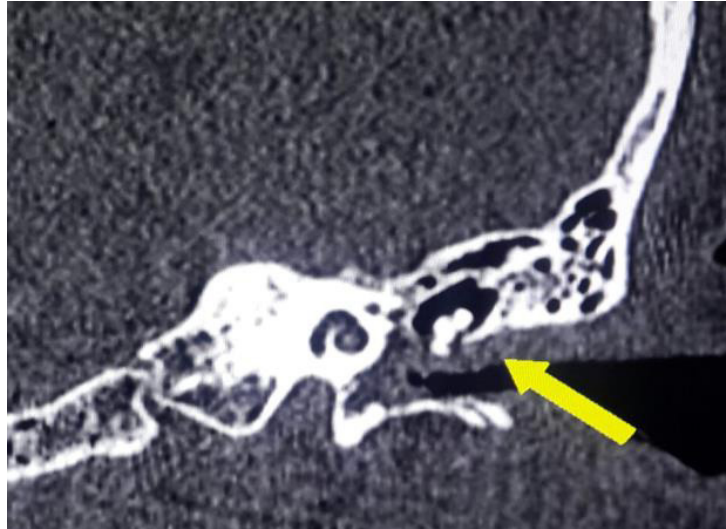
Coronal reformat of an adult patient with chronic right ear discharge. CT image reveals atico-antral opacification of right temporal bone with involvement of middle ear cavity. The scutum tip is relatively blunt and raised strong suspicion of cholesteatoma.
